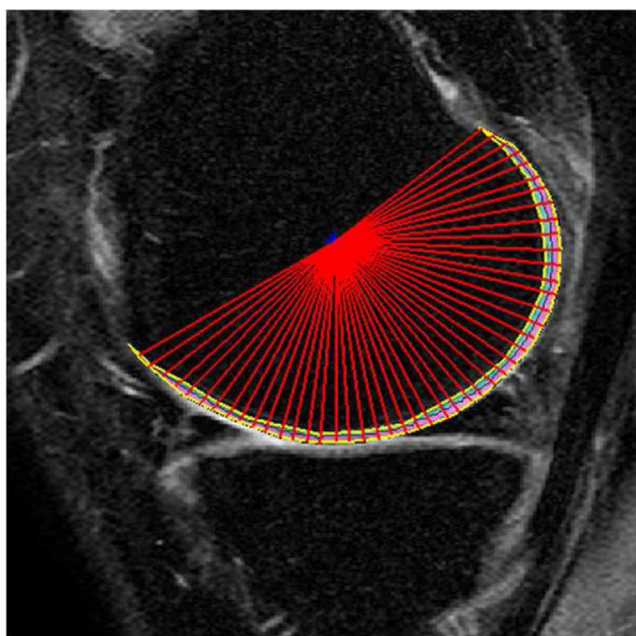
Sagittal SPGR images from T1rho sequence of knee MRI after manual segmentation with post-processing. Two observers segmented the entire femoral cartilage of the both images slice by slice independently. After manual segmentation, angular analysis in step of 4-degree and depth analysis with superficial and deep layers was performed automatically.
